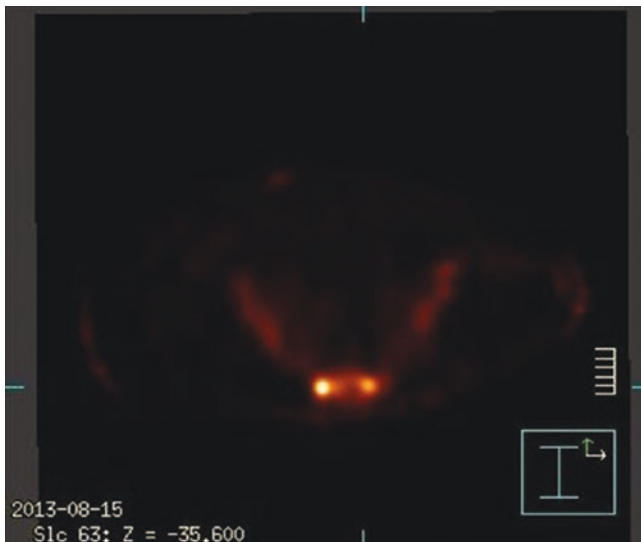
SPECT/CT showing symmetric sacral uptake without the horizontal strut in sacral insufficiency fractures. (Reproduced with permission from Dr. Leo Ha)
